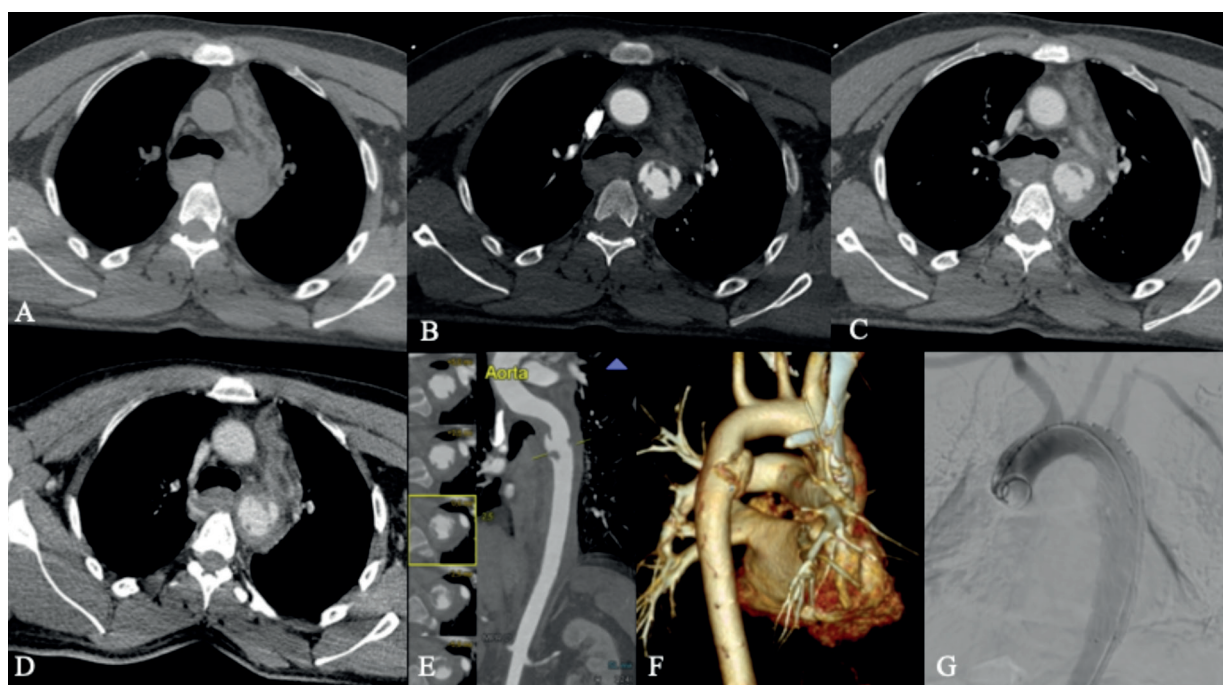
Traumatic aortic pseudoaneurysm in a clinically unstable 40-year-old man. (A) Absence of hyperattenuating material on non-enhanced scan. (B) Angiographic CT phase shows irregularities along the inferior surface of the aortic isthmus. (C, D) Venous phase and delayed phase exclude contrast pooling. (E, MPR curve and F, VRT demonstrate a smooth-walled pouch adjacent to the aorta and are useful for surgical planning. (G, Angiographic scan during endovascular surgery.
